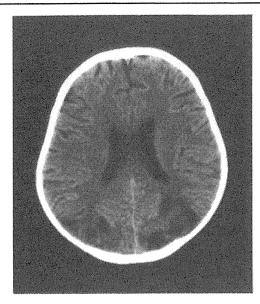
Cranial CT images of the same patient. Distinct low-density areas are shown in the corresponding areas of Figs. 1 and 2.
